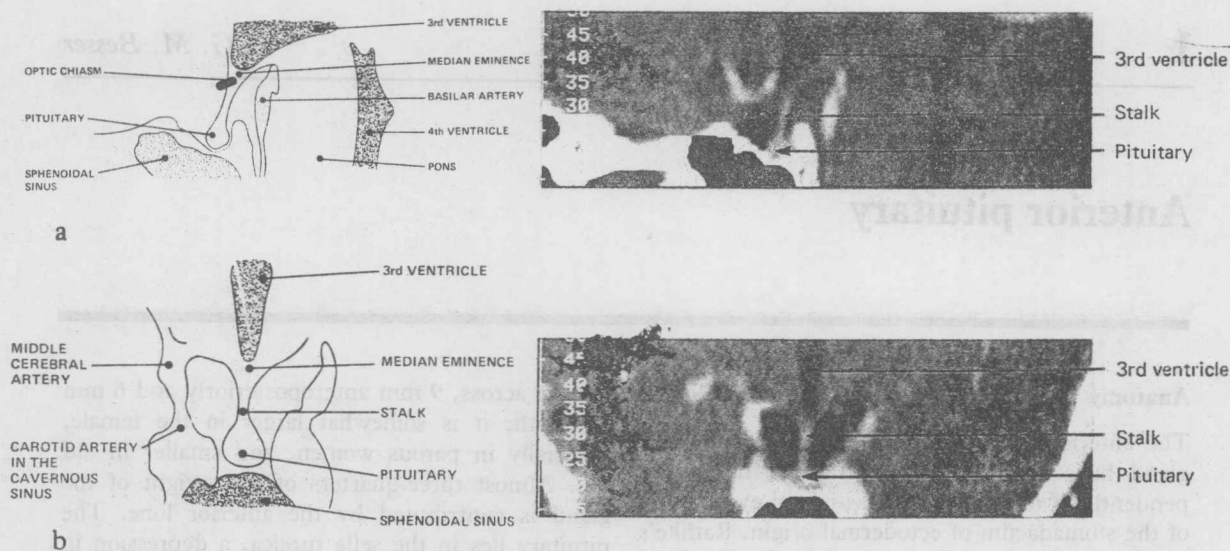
(a) sagittal and (b) coronal reconstructions of CT scan of anterior hypothalamus and small pituitary gland in a normal subject showing the anatomical relationships. I.V. contrast has been given to show up surrounding arteries and the vascular pituitary stalk and gland. This should be compared with Figure 1.1.
